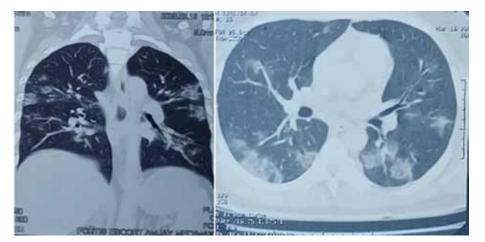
CT scan - Multifocal patchy peripheral and sub pleural area of air space ground glass opacities in both lung parenchyma, involving posterior
